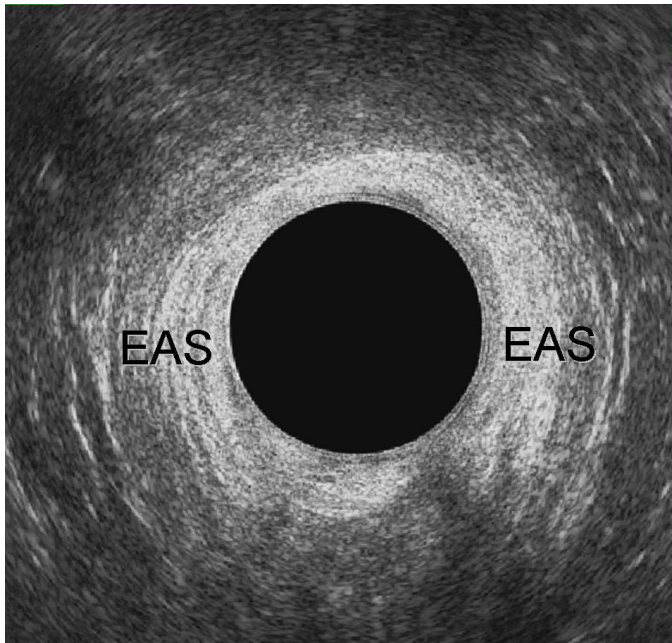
Endoanal ultrasonography. (a) Upper level of the anal canal; (b) Middle level of the anal canal; (c) Lower level of the anal canal. PR= puborectalis; IAS= internal anal sphincter; EAS= external anal sphincter; LM= longitudinal muscle; SE= sub epithelium
